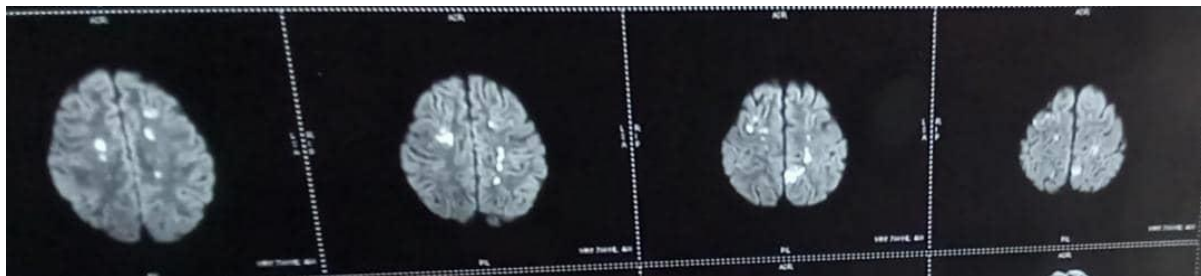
Coronal view of Brain MRI showing multiple small foci of restricted diffusion in both cerebral hemispheres
